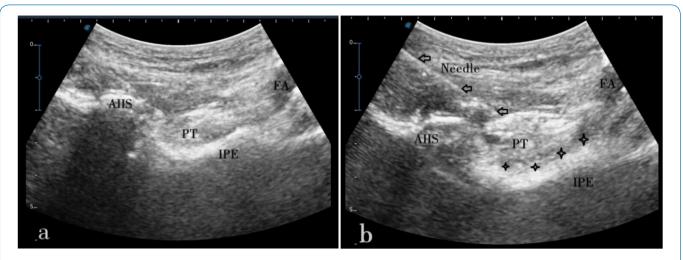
Ultrasound image of the PENG block. (a) Ultrasonic anatomy of the PENG block; (b)The needle path and the diffusion of local anesthetics. ASIS, anterior inferior iliac spine; FA, femoral artery; PT, psoas tendon; IPE, iliopectal eminence; Needle, puncture needle pathway.
